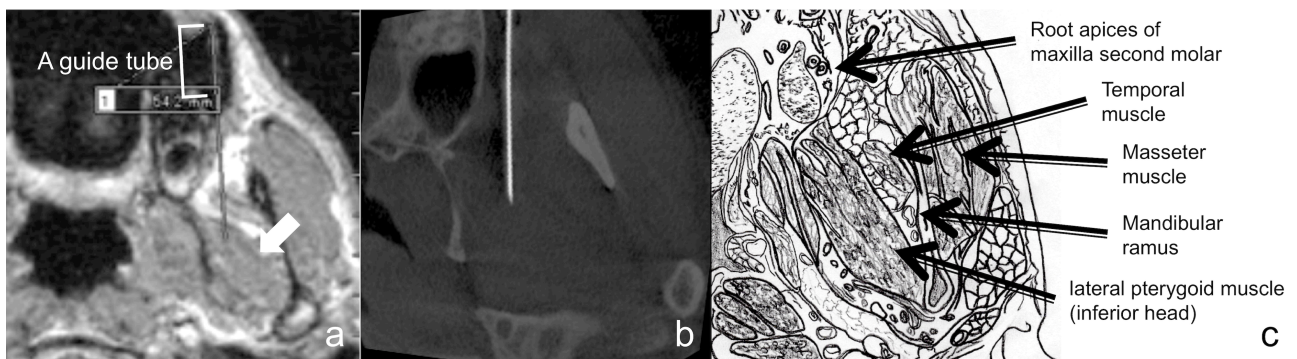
(a) An example of a magnetic resonance (MR) image of a subject wearing a resin splint with a guide tube, which was used to determine the direction and distance for the insertion of the needle electrode. The arrow shows the lateral pterygoid muscle. (b) An example of the cone-beam computed tomography (CBCT) image of the same subject, confirming the placement of the electrode in the lateral pterygoid muscle. The arrow shows the lateral pterygoid muscle. (c) Scheme of the cross-section around the lateral pterygoid muscle.
